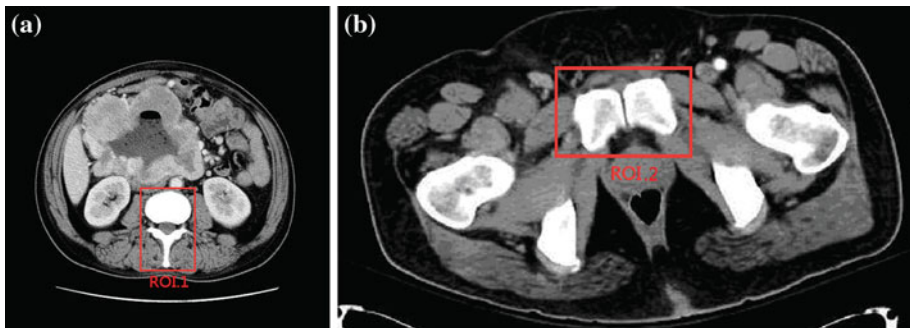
The tested CT imageries for the ISCEM extension for multiple objects. a The selected ROI 1 showing the vertebra body and vertebra spinous process from the CT image, b the selected ROI 2 with two enhanced objects from the CT image of pulmonary embolism
